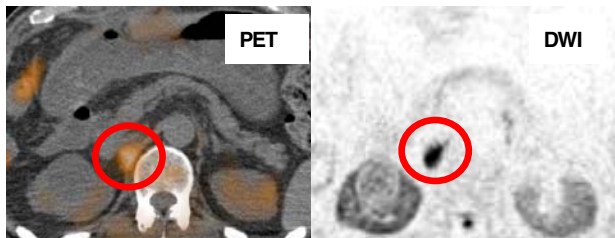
The case that was detected lymph node by both DWI and PET. (80y.o., male, rectal carcinoma)
